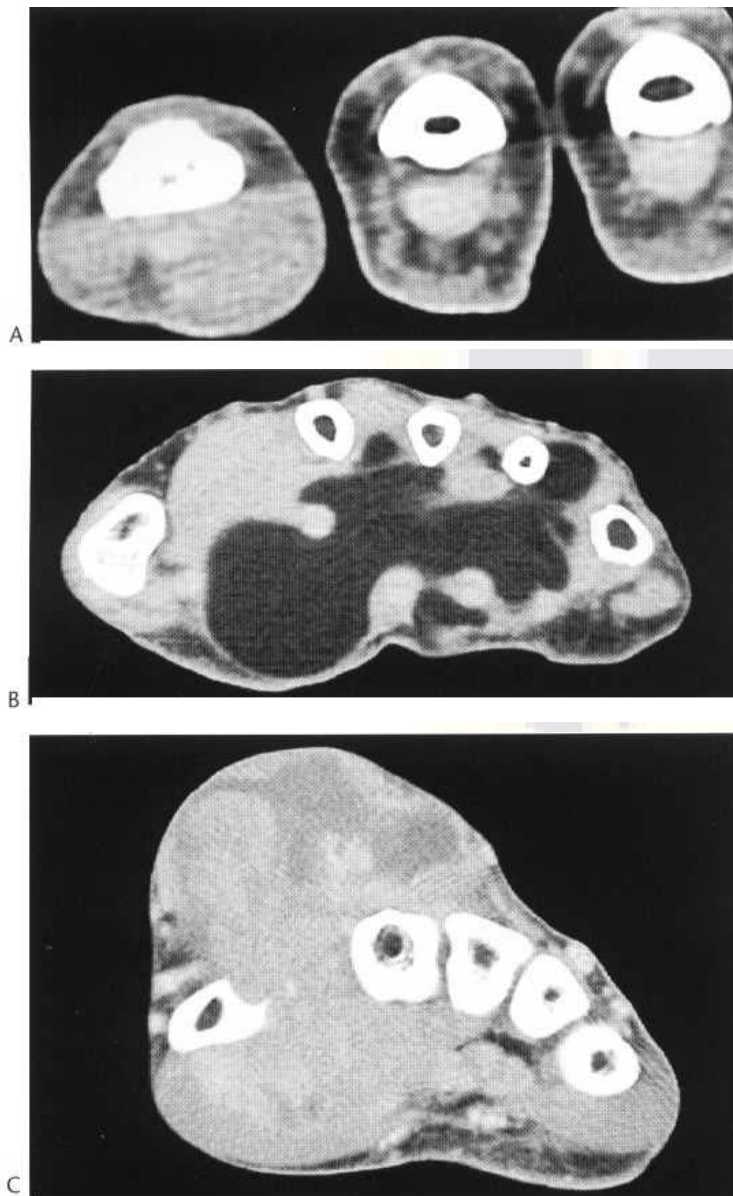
CT images of the hand. (A) Giant cell tumour encasing the flexor tendon of the little finger. (B) Lipoma of the palm, interdigitating between the flexor tendons and metacarpals. (C) Soft-tissue sarcoma arising in the hand.
